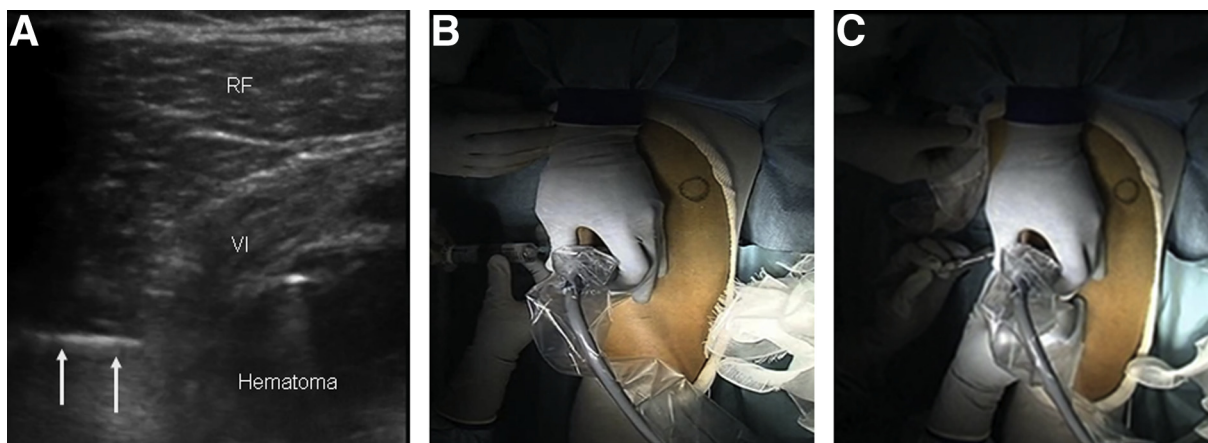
Preparation of ultrasonography-guided muscle hematoma evacuation. (A) Local anesthesia on the right thigh is performed. The needle is visualized as it goes through the muscle. Rectus femoris (RF) and vastus intermedius (VI) muscles are shown. The optimal depth of the needle (white arrows) is determined on ultrasonography. (B) Infiltration of 2% xylocaine is done. (C) An incision of 1 cm in length and dilation with a mosquito clamp are performed after infiltration of the anesthetic.
